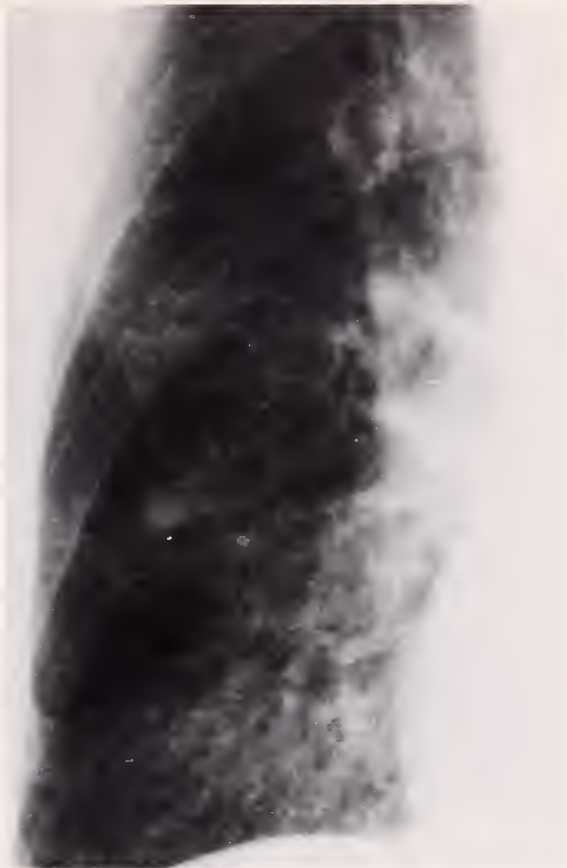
(A) Chest radiograph of a 79-year-old Hispanic man with disseminated coccidioidomycosis shows a diffuse miliary nodular pattern throughout both lungs. (B) Close-up of right lung better shows the diffuse miliary nodular pattern.
